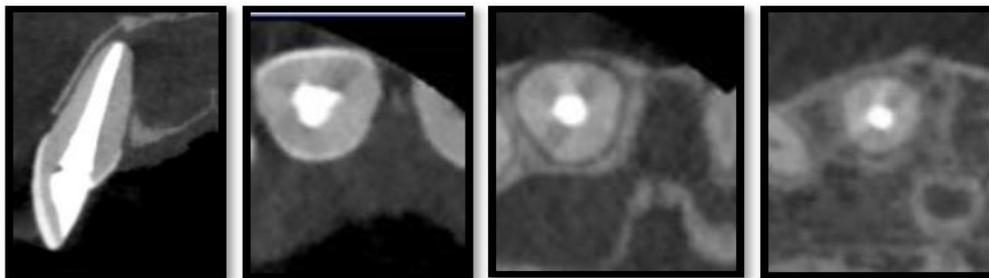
CBCT Images at Saggital, Coronal, Middle And Apical Section
